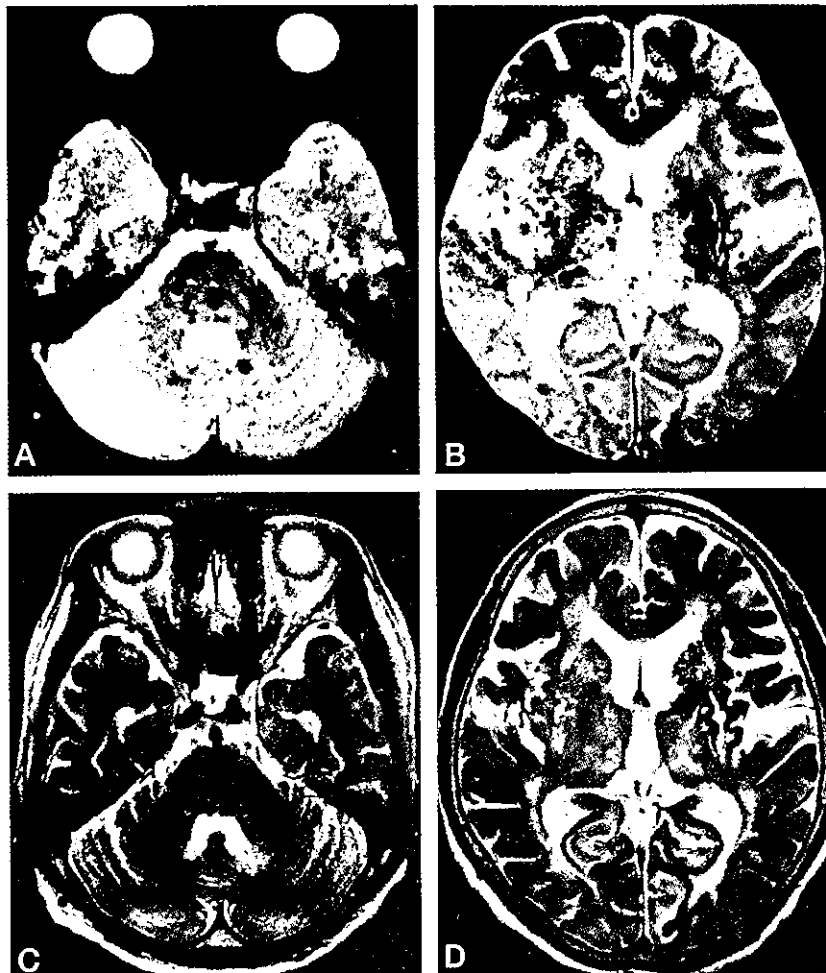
MR images of a 75-year-old patient with intracerebral hemorrhage in the right parietal lobe 8 years after the occurrence of intracerebral hemorrhage in the left putamen.
